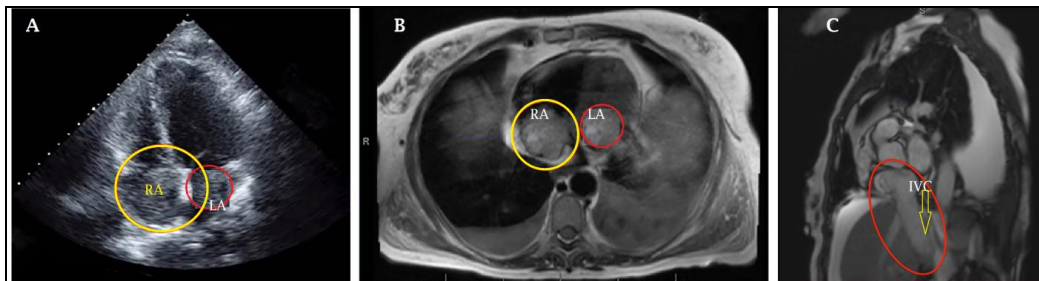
Biatrial secondary mass seen in 2D Echocardiogram, Figure 1B. Biatrial secondary mass seen in Cardiac MRI, Figure 1C. Sagittal oblique T2-weighted MRI of the chest revealed filling defect in the inferior vena cava from the level of the renal veins into the right atrium. No hepatic mass was present.
